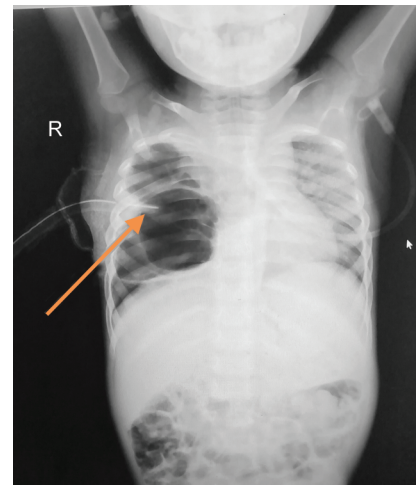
Chest X-ray showing intercostal drainage tube in the cavity
